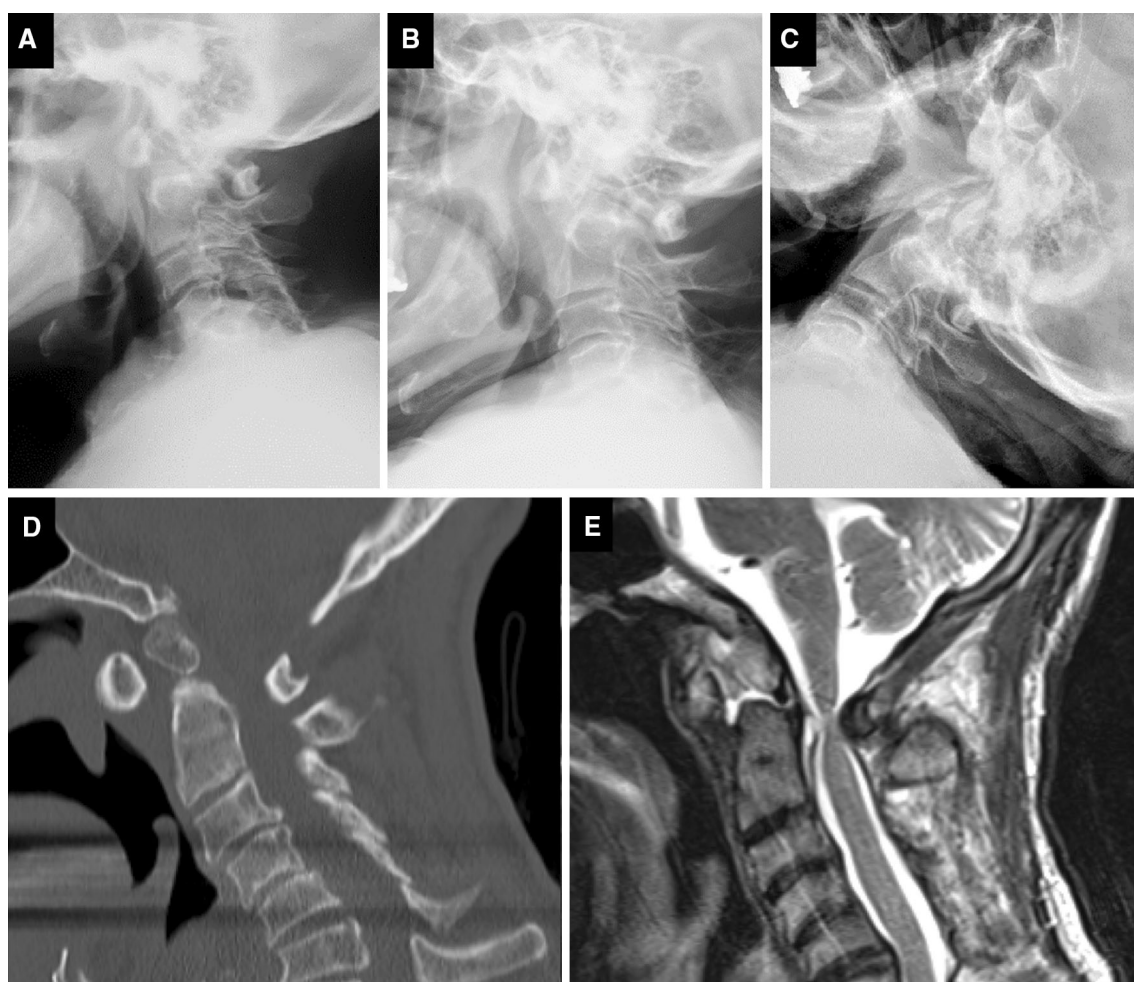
Preoperative lateral radiographs in neutral (a), flexion (b), and extension positions (c). Sagittal CT shows os odontoideum (d). MRI shows severe spinal cord compression at C1–2 (e)
